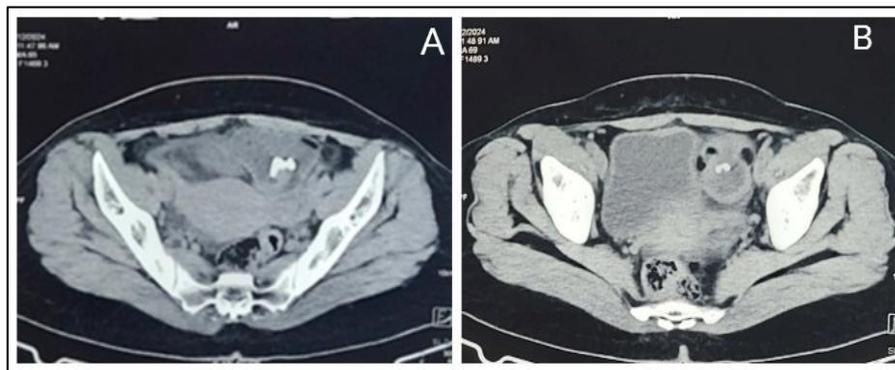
Axial CT section at the level of the pelvis shows a mass in the left adnexa with internal fat, fluid, and calcification, consistent with a dermoid cyst.
